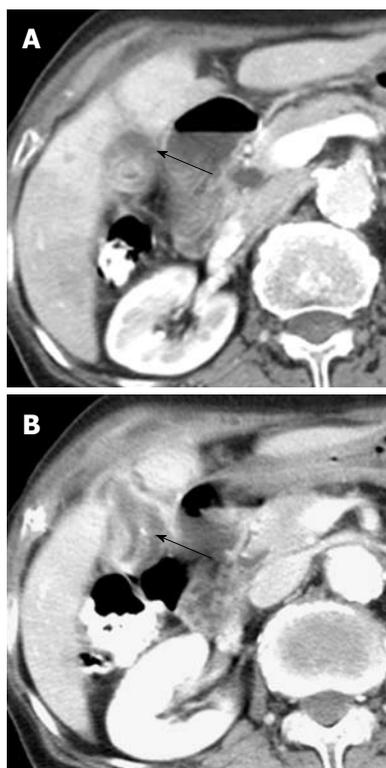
Mucinous carcinoma of the gallbladder in a 77-year-old woman. A: Contrast-enhanced CT image shows localized wall thickening (arrow) in the body of the gallbladder containing a suspicious mucin pool; B: Contrast-enhanced CT image inferior to (A) shows a punctate calcification and localized wall thickening (arrow) in a mildly distended gallbladder. CT: Computed tomography.
